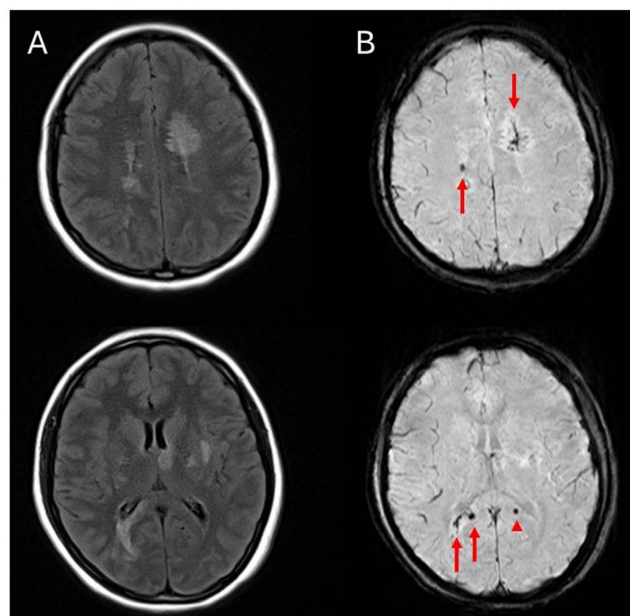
Microhemorrhages in the areas of T2 hyperintensities. (A) and (B), Axial slices of T2 FLAIR sequences (A) and susceptibility-weighted imaging (B) at two different levels demonstrate the extent and variability of periventricular and juxtacortical T2 hyperintensities (A), with areas of hypointensity (B) inside (arrows) and outside (arrowhead) the areas of T2 hyperintensity.
